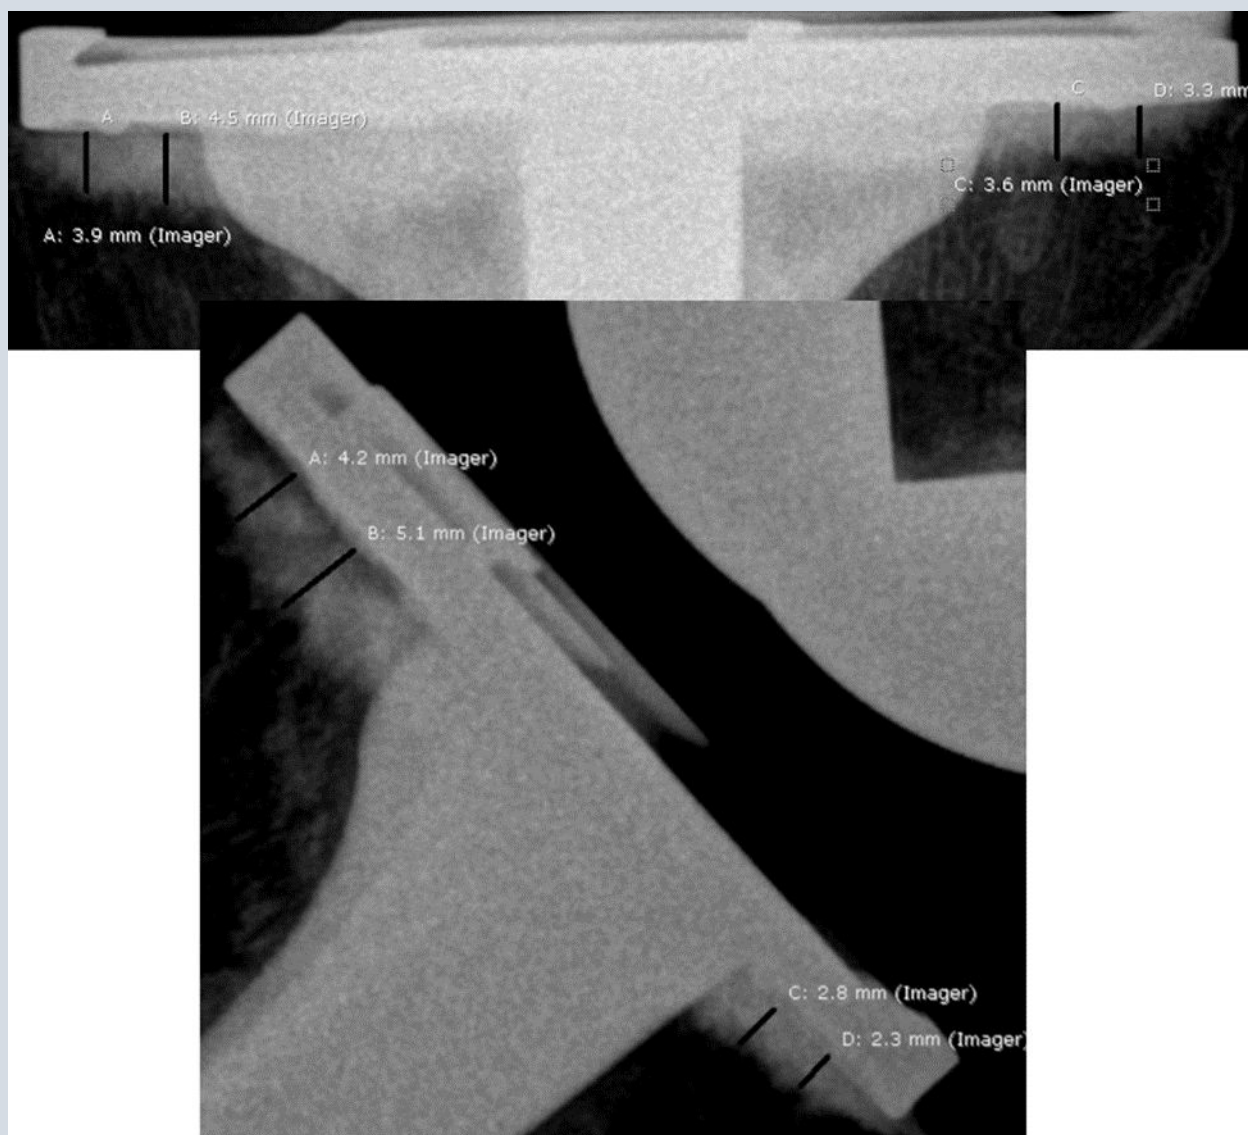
Example Tibial Cement Penetration Depth Measurement on AP and Lateral X-rays.
